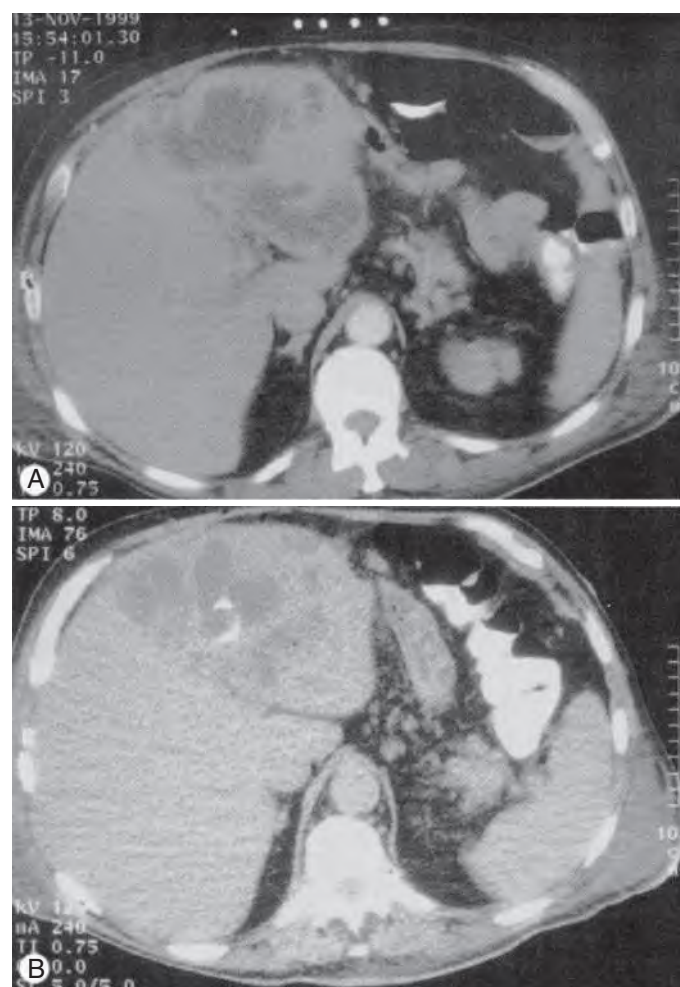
Drainage of liver abscesses by percutaneous aspiration guided by computed tomography (CT). A 67-year-old man with a history of diabetes mellitus and rheumatoid arthritis and a distant history of a Billroth II gastric resection, recently diagnosed with adenocarcinoma of the stomach, presented with fever. A blood culture grew *Escherichia coli*. The liver was imaged by CT (A), revealing multiple hypodense lesions in the right hepatic lobe. The lesion was aspirated under radiologic guidance, and more than 500 mL of frank pus were drained. Cultures produced *E. coli* and several anaerobic bacterial species. Cytologic findings were consistent with metastatic adenocarcinoma. A radiodense percutaneous drainage catheter was left in place (B), and the patient was treated with intravenous antibiotics and continued drainage. (Note the position of the catheter and the decrease in size of the abscess. [Courtesy Lindsey Baden, MD, Brigham and Women's Hospital, Boston. From Johannsen EC, Sifri CD, Madoff LC. Pyogenic liver abscesses. *Infect Dis Clin North Am.* 2000;14:547–563, vii.]
